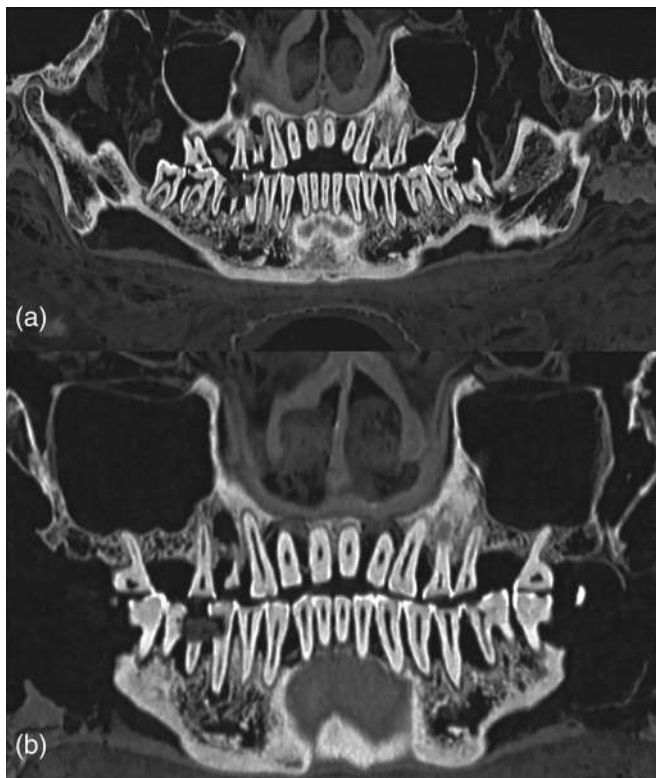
Curved multiplanar reconstructions of the mandible (a) and maxilla (b) showing tooth wearing, periodontitis, and periapical lucencies
